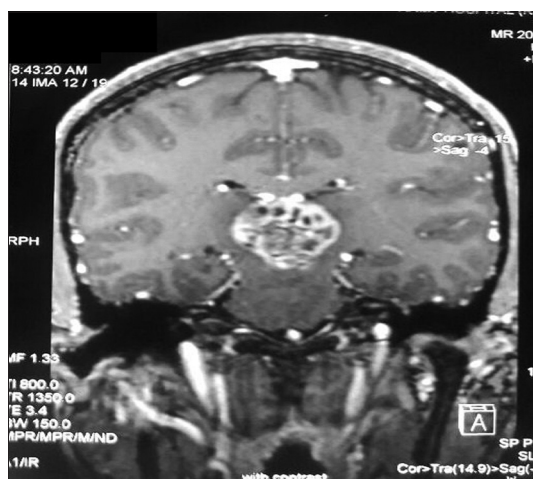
Magnetic resonance imaging of pineal tumor
